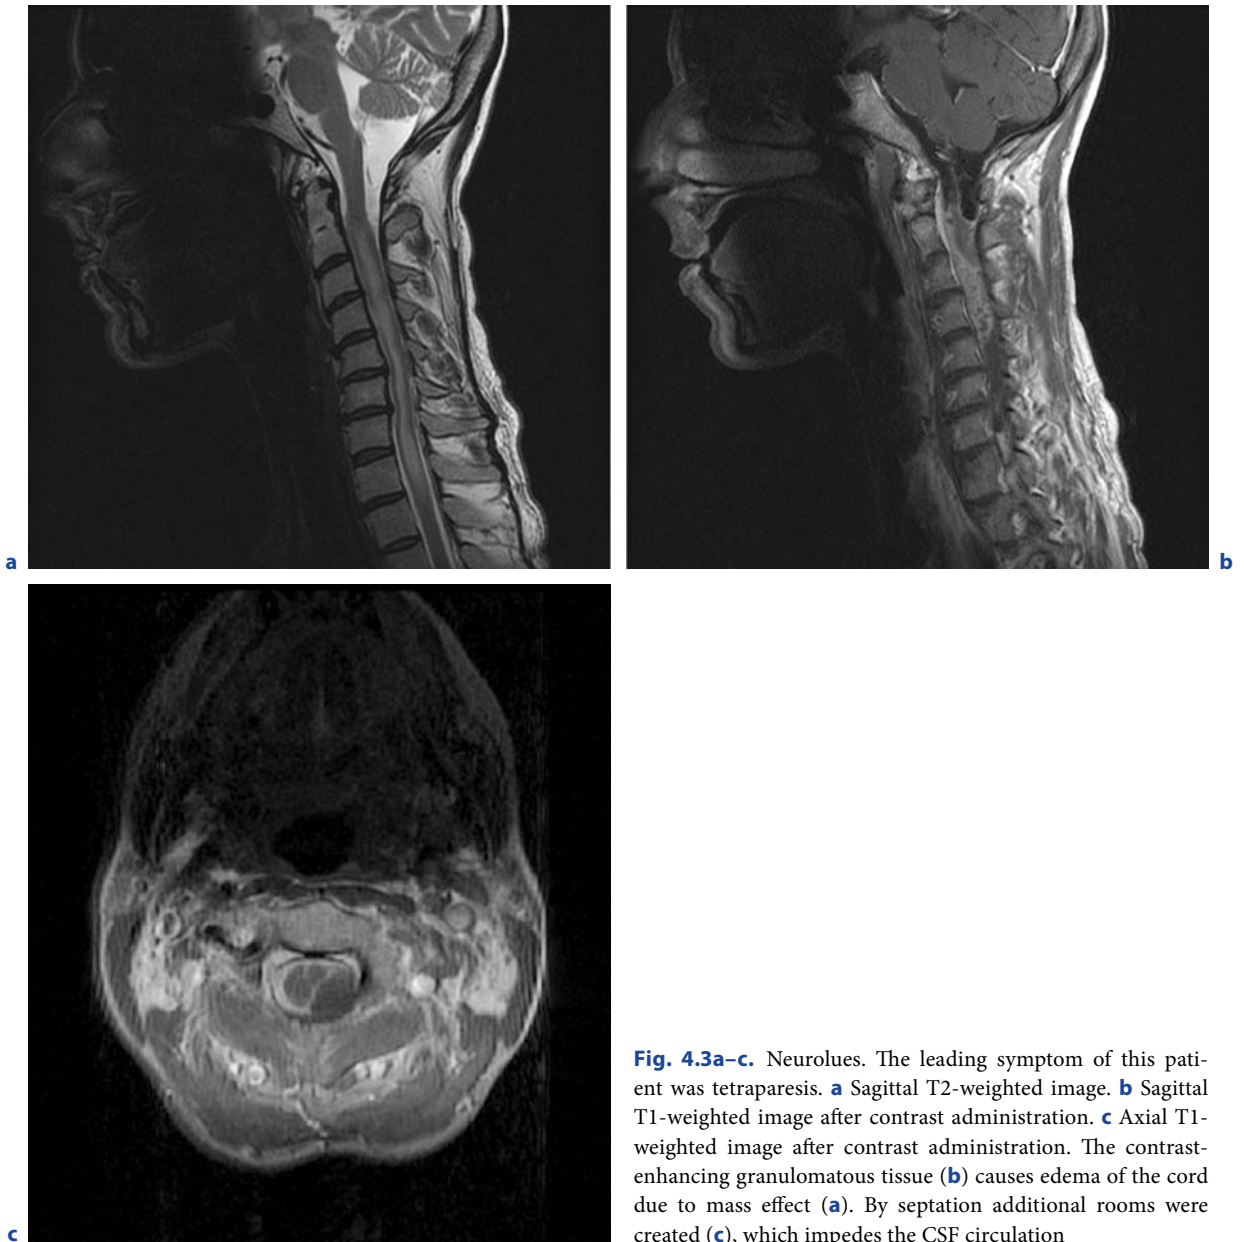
Neurolysis. The leading symptom of this patient was tetraparesis. a Sagittal T2-weighted image. b Sagittal T1-weighted image after contrast administration. c Axial T1-weighted image after contrast administration. The contrast-enhancing granulomatous tissue (b) causes edema of the cord due to mass effect (a). By septation additional rooms were created (c), which impedes the CSF circulation
